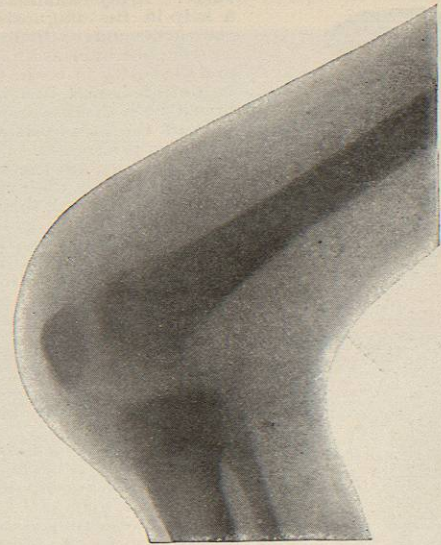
Radiograph of same Case as Fig. 3012, showing Indistinctness of Lower End of Femur, where Focus of Disease is Situated.
